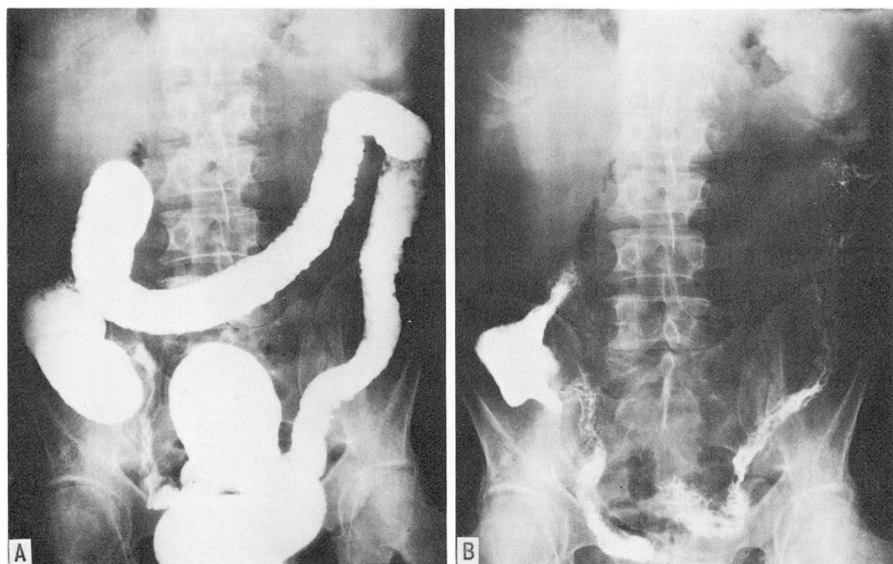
Case 1 (7-30-57). A, Roentgenogram after barium enema, showing loss of haustral markings and evidence of ulceration. B, Evacuation roentgenogram after barium enema, showing distorted mucosal pattern.
